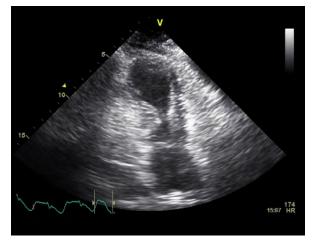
Echocardiographic apical 2-chamber view shows apical akinesis and a hypercontractile base in the same patient (Fig. 2). Supplemental motion image is available for Figure 5.
